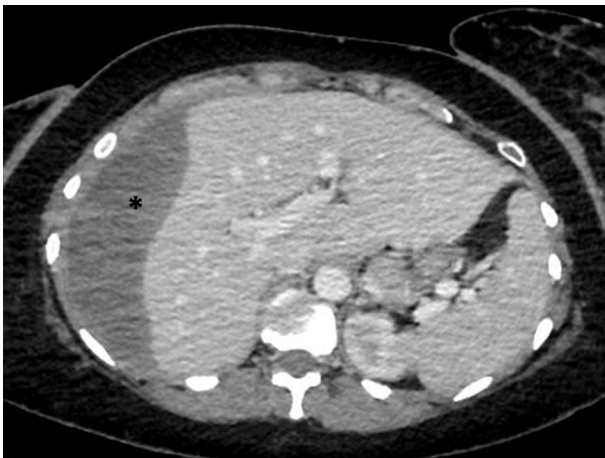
Axial abdominal computed tomography with contrast at day 8 postpartum: persistence of a right hepatic subcapsular collection of more homogeneous density indicated by a black star, still measuring 44 mm × 160 mm.
